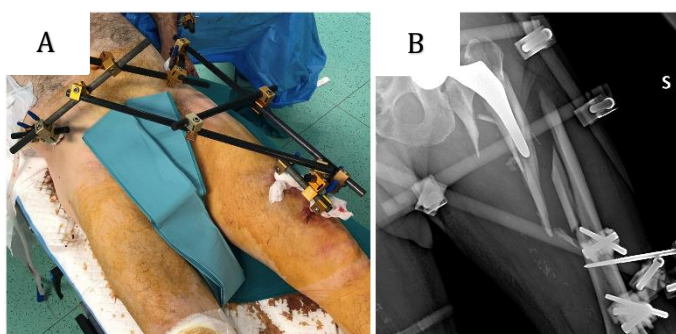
(A) Early stabilization of the fracture with external fixation and (B) postoperative x-ray
